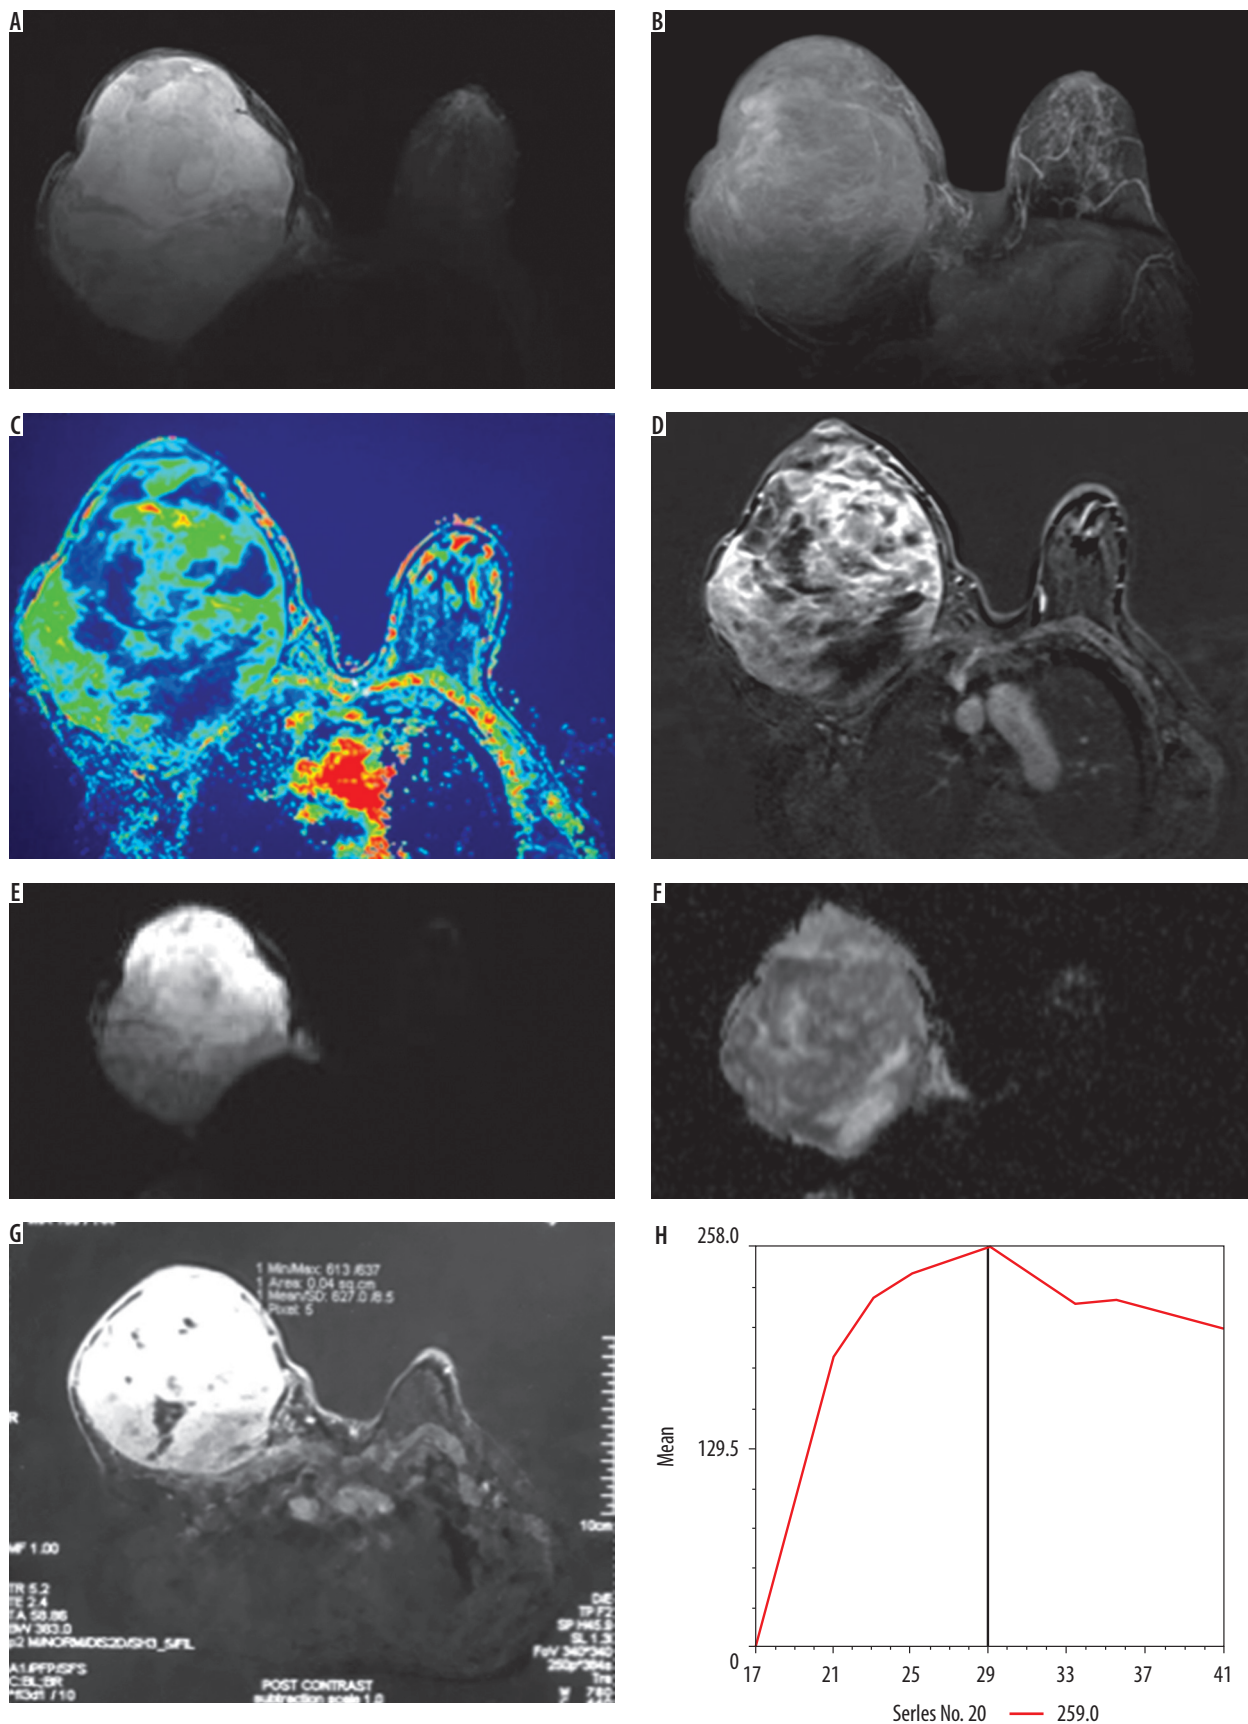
Magnetic resonance imaging breast in a case of malignant phyllodes in a 40-year-old woman. A) Axial T2WI showing a large heterogenous mass in the right breast. B) Maximum intensity projection image showing heterogeneous enhancement of the lesion. C) Wash-in colour map showing early enhancement of the mass. D) Post-contrast axial fat sat T1WI image showing intense heterogenous enhancement of the mass. E) Axial diffusion weighted imaging (DWI) showing hyperintense signals in the mass with F) corresponding low apparent diffusion coefficient value (restriction on DWI). G-H) Time signal intensity curve of the mass showed type III kinetic curve (early washout)
